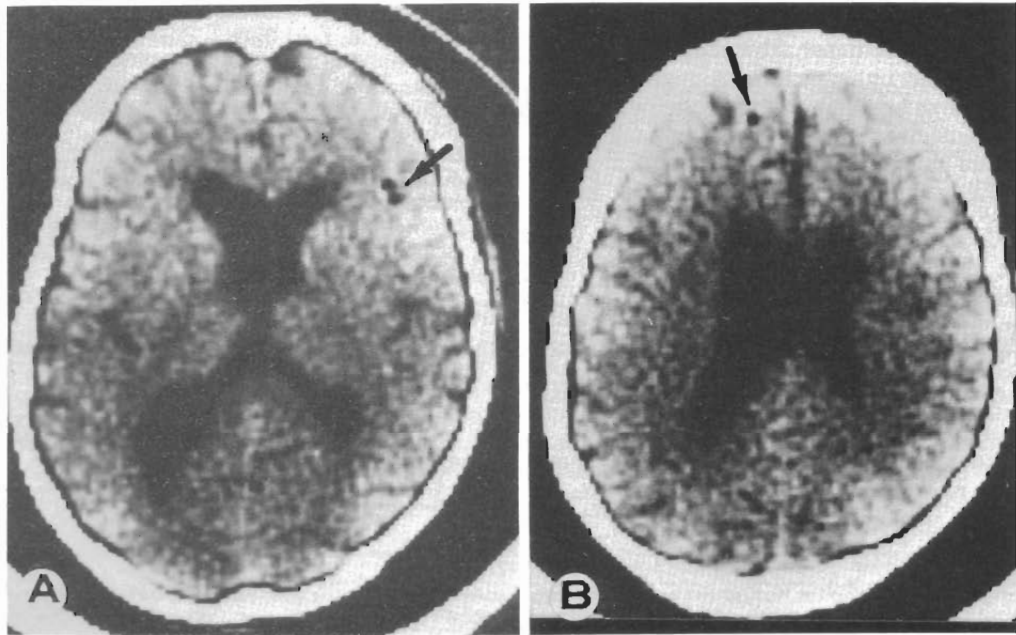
Computed tomographic scan of the head after paradoxical air embolism shows punctate areas of lucency in (A) the middle cerebral artery territory, and (B) the anterior artery territory.
